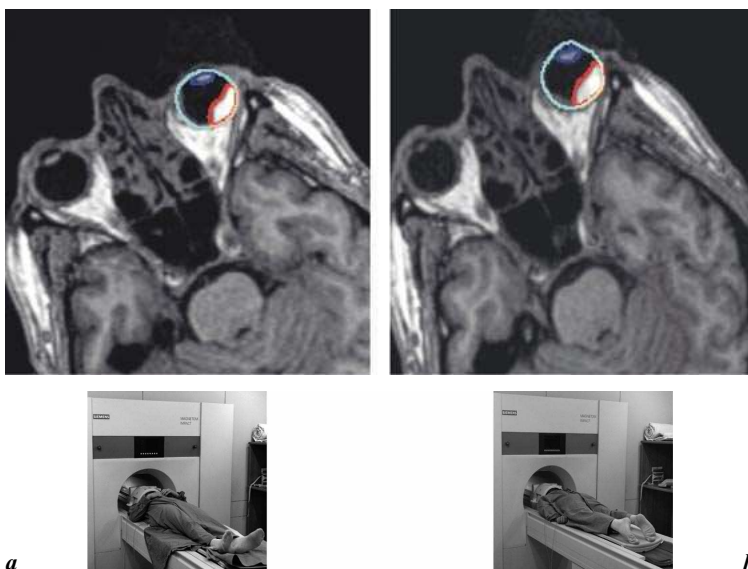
Evaluation of potential discrepancies between prone and supine MRI. Three volumes including eye, tumor and eye lens were outlined on MRI done in patient supine position (a) and then projected to MRI done in patient prone position (b). To assess also the stability of eye fixation these two subsequent imaging were done in at least 2 h interval.
